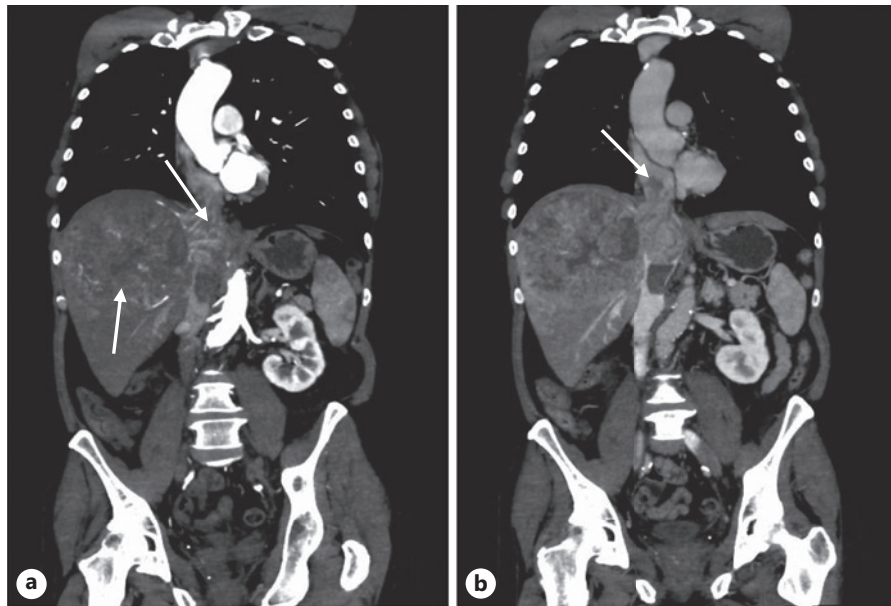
a Arterial-phase CT scan in coronal plane of the thoracic and abdominal cavity showing extensive HCC in the right lobe of the liver with a TT invading the IVC (white arrows). b Venous-phase CT scan in coronal plane of thoracic cavity showing TT in RA (white arrow).
